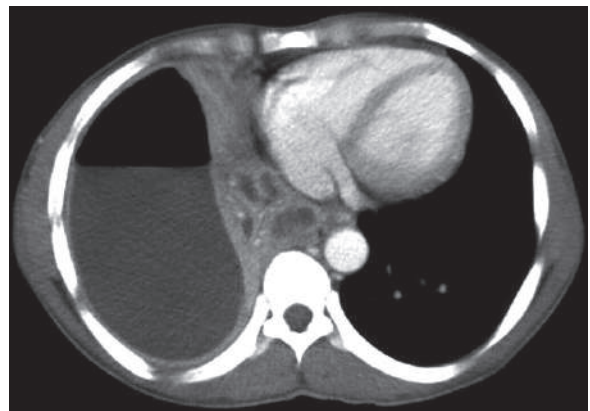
Axial chest CT shows huge right bronchopulmonary fistula
